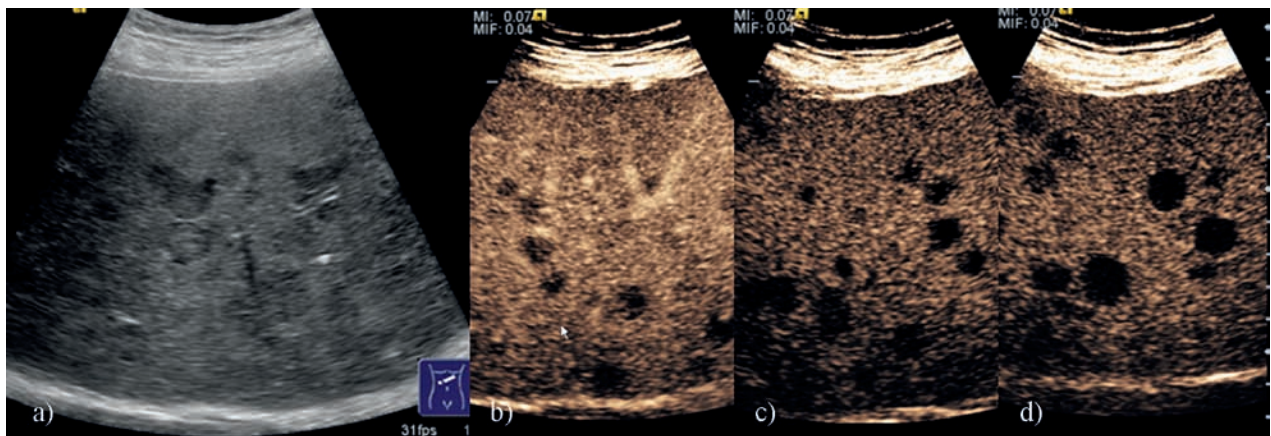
Liver metastases – CEUS examination: a. Standard ultrasound – globally inhomogeneous liver structure, with multiple, small hypoechoic nodules; b. Portal-venous phase – multiple hypoenhancing nodules; c, d Late phase – hypoenhancing small nodules.
